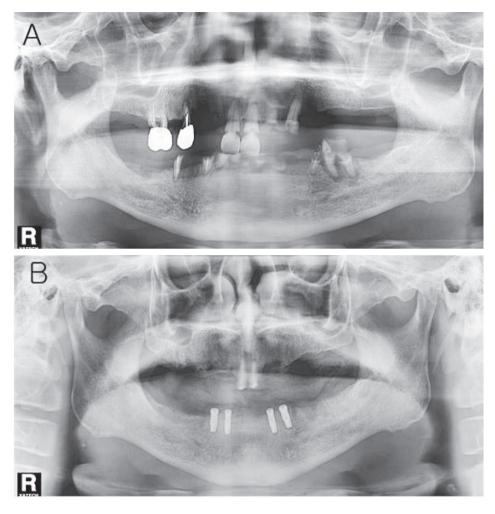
A. Pre-rehabilitation state, panoramic radiograph reveals that patient has been under terminal stage of chronic periodontitis and severe dental caries. B. The final radiograph shows four implants were installed in mandibular symphyseal region for an overdenture and the roots of #11 and 21 teeth were preserved for maxillary full denture.
